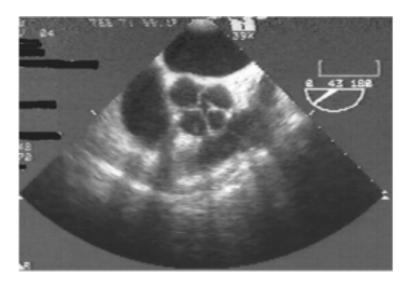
Short-axis view of the aortic valve on transesophageal echocardiography.
